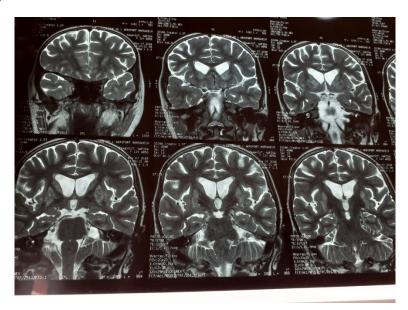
Coronal section of a brain MRI showing a T2 hypersignal of the caudate and lenticular nuclei bilaterally and symmetrically with secondary hemorrhagic infarction, in a child with dystonia: image in favour of a neurowilson.
